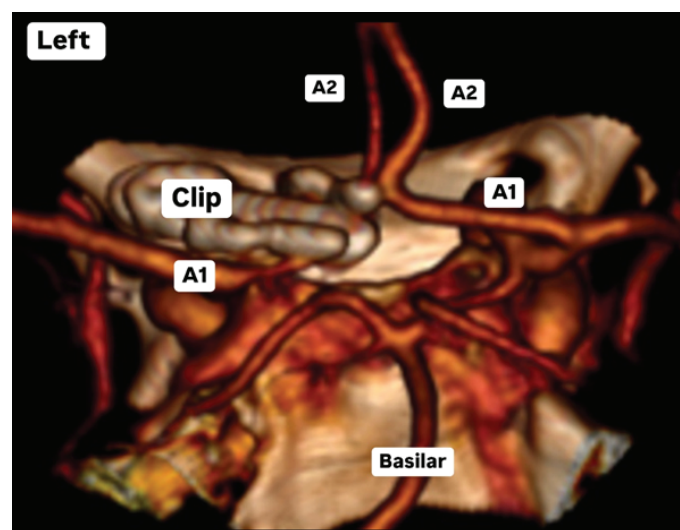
3D reconstruction from postoperative angio-CT, posteroanterior view, showing aneurysm clipping and bilateral preservation of flow in the A2 segments of the anterior cerebral artery.
